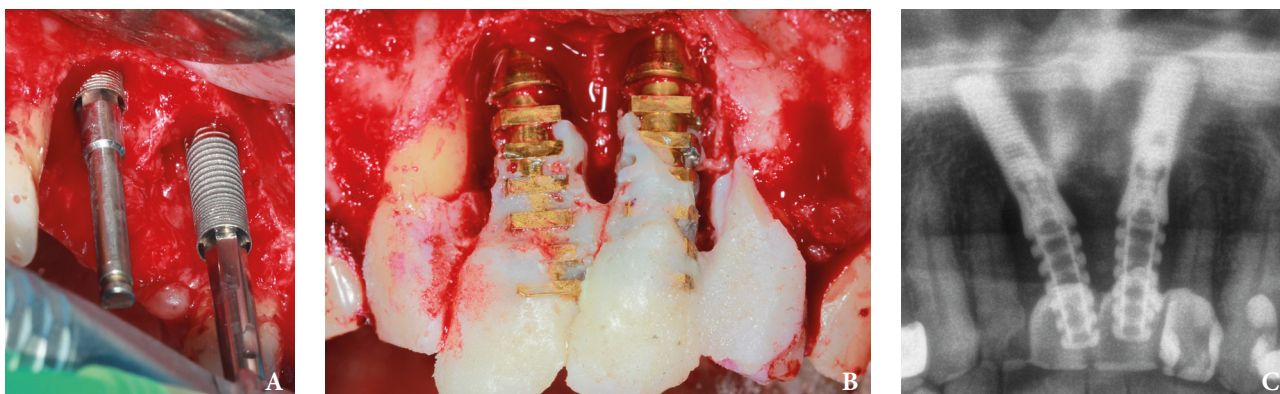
Intraoperative view at the stages of dental implants placement (A) and producing of temporary crowns (B). Post-operative cropped panoramic radiography (C).
